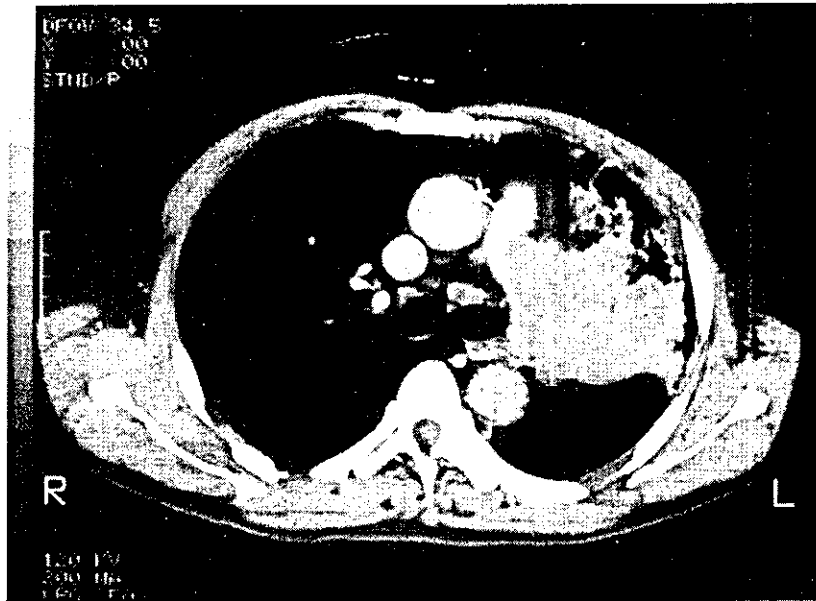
Computed tomography results of the chest before treatment (mediastinum window). A huge mass was found in the left lung and a small nodule was found in the mediastinum.
